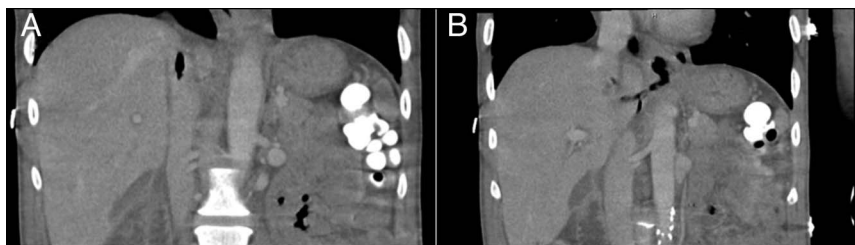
Abdominal computed tomography showing (A) air and (B) a fistulous tract between the distal esophagus near the gastroesophageal junction and the proximal hepatic IVC. IVC, inferior vena cava
